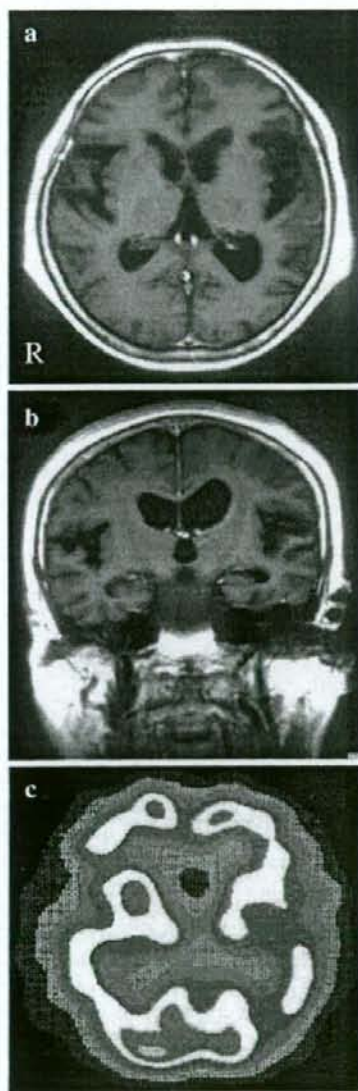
T1-weighted MRI and 123I-IMP-SPECT images. T1-weighted MRI revealed severe atrophy of the left temporal lobe and dilatation of the left Sylvian fissure (a, b). Hypoperfusion was noted in the left perisylvian area (c). The right side is shown on the left-hand side of each figure.
